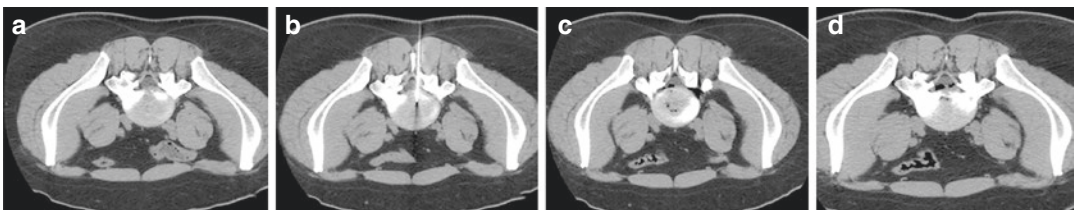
(a) Patient in the prone position; right paramedian lateral herniated disk with thecal compression. (b) Under CT guidance with a transligament approach, the disk at the L5-S1 level is reached. (c, d) The gas mixture O_2-O_3 is
